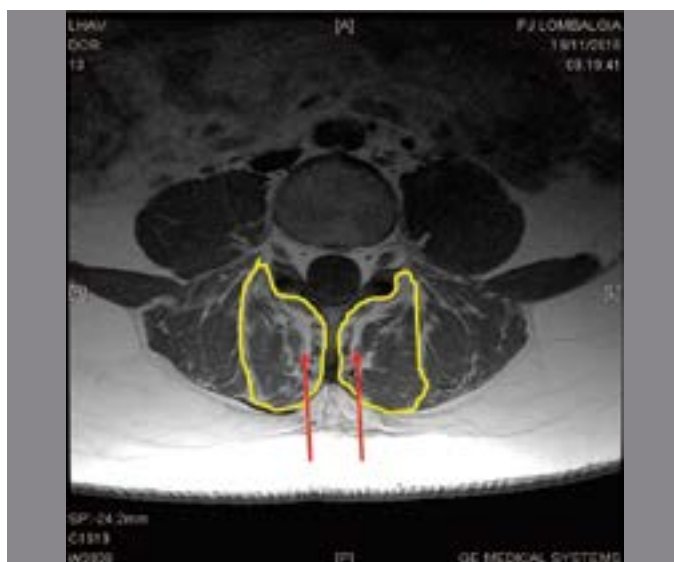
Axial T1-weighted image shows the lumbar multifidus in L5. The dashed line delimits the multifidus lumbar muscle, the arrows point to the fat infiltration.
